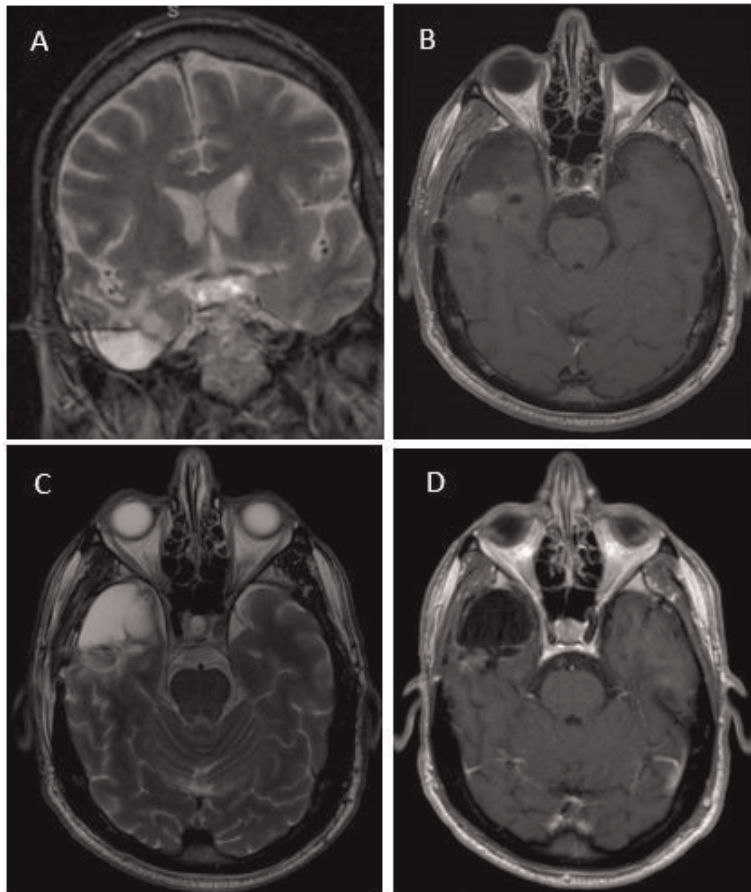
A 55-year-old gentleman presenting with asymptomatic GBM recurrence. Intraoperative T2-weighted sagittal MRI showing stereotactic placement of laser probe at target lesion (A). Postoperative day 1 of T1-weighted axial MRI with contrast demonstrates gross total lesion ablation; hyperintense signal most likely represents blood products (B) instead of residual tumor, as the same region does not enhance on T2-weighted MRI (C). At 22-months follow-up, T1-weighted axial MRI imaging with contrast showed the patient was recurrence-free (D).
